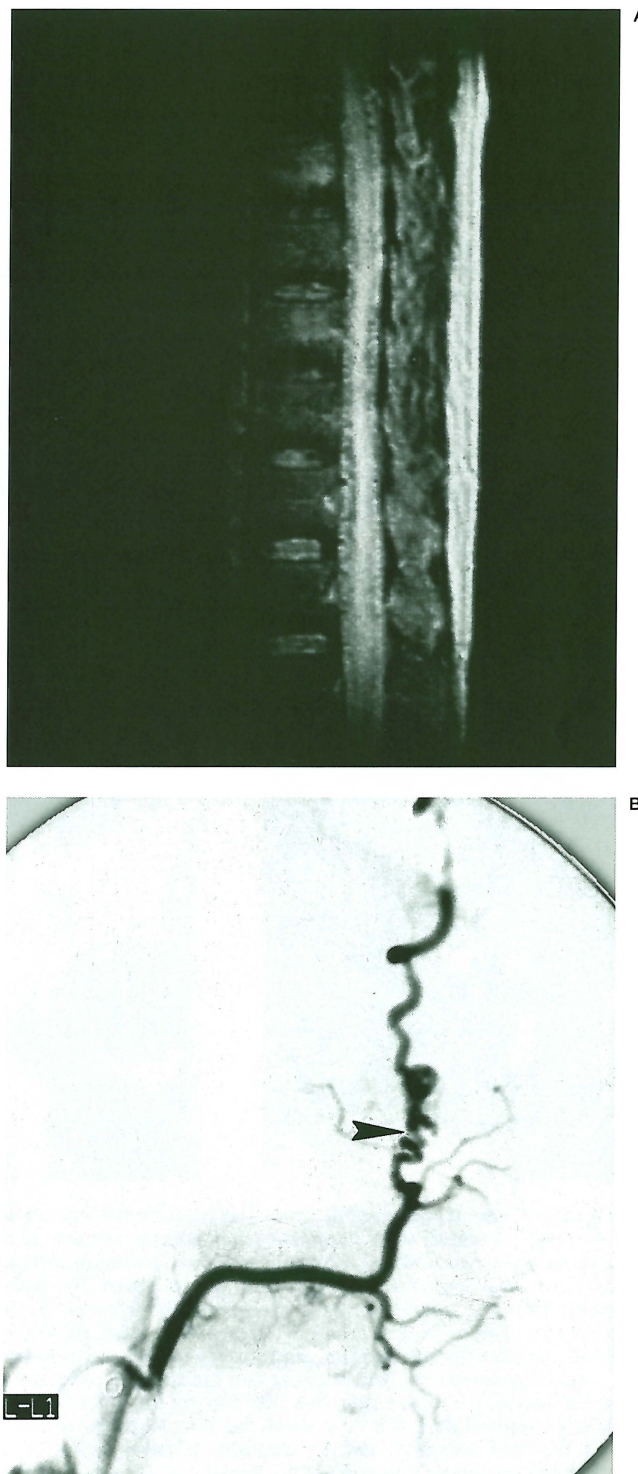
SDAVF treated by NBCA embolisation. A 65-year-old male presented with progressive paraparesis for one year. A) A sagittal T2-weighted MR image shows the hyperintensity signal in the thoracic cord which is related to oedema. B) Selective angiography of the left L1 lumbar artery in lateral view shows the fistula (arrowhead) supplied by a dilated dural artery and draining to the medullary vein.
